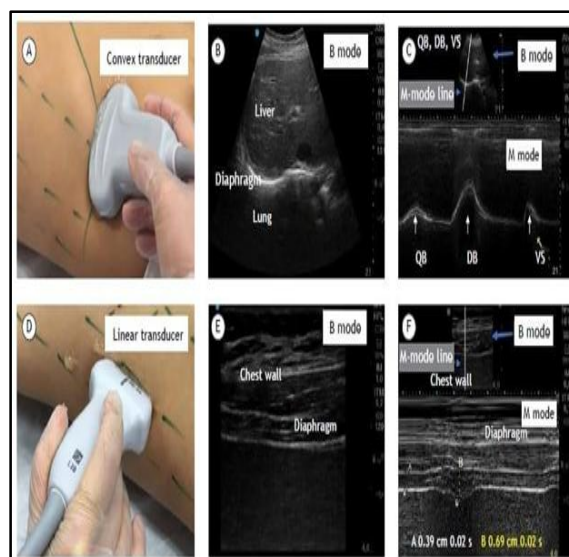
Surface anatomy and probe positioning for diaphragmatic ultrasonography using a linear transducer over the anterior/mid-axillary line at the 8th–9th intercostal space.
